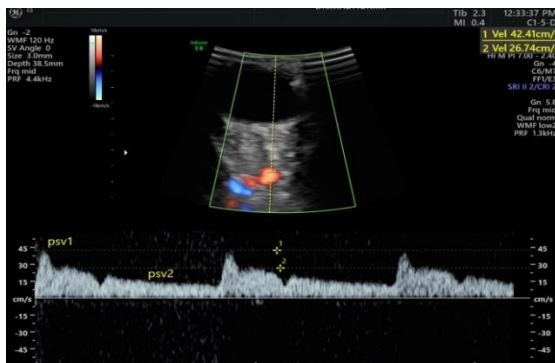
Representative image of ophthalmic artery Doppler waveform in a hypertensive woman.
